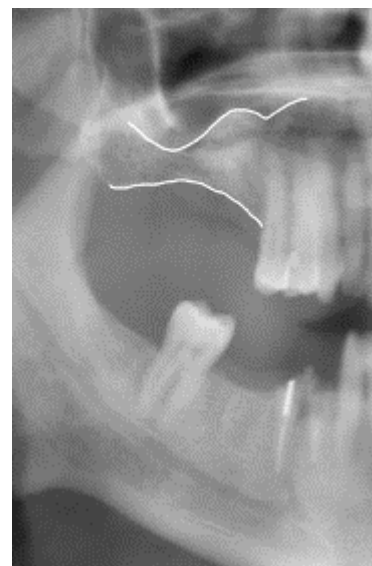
Pre-operative OPG radiograph showing severe vertical bone loss due to maxillary sinus pneumatization in area of #16 with a mean residual bone height of less than 4 mm.
